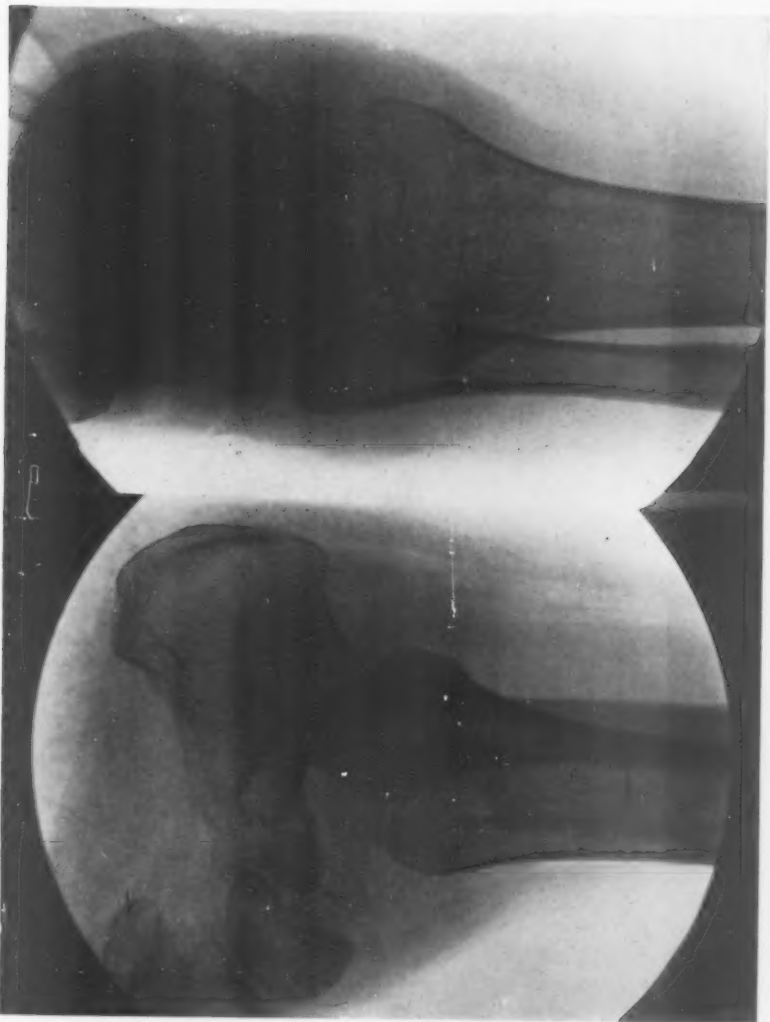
Case II (Pathol. No. 21340, Old No. 22920). X-ray showing recurrence with destruction of the articular surface of the tibia after the removal of the central myxoma of the astragalus piece.
